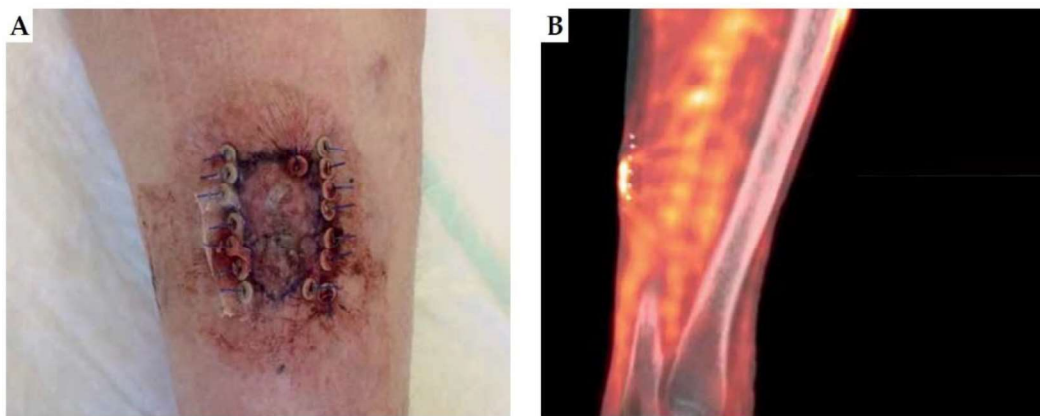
A) Final appearance of lesion A one day after treatment; B) Fusion between the pretreatment PET/CT and the CT performed after the implant
